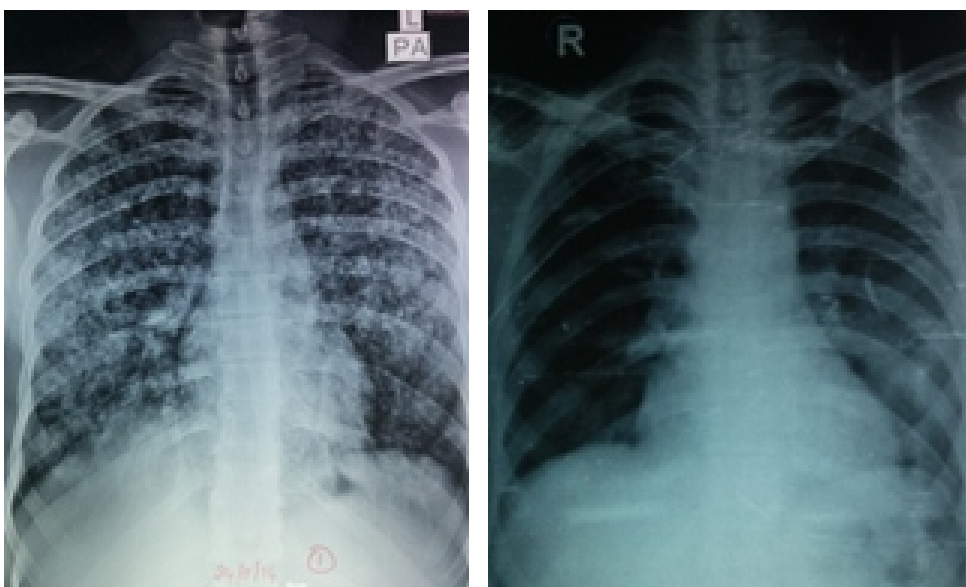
Chest xray Before and After treatment
